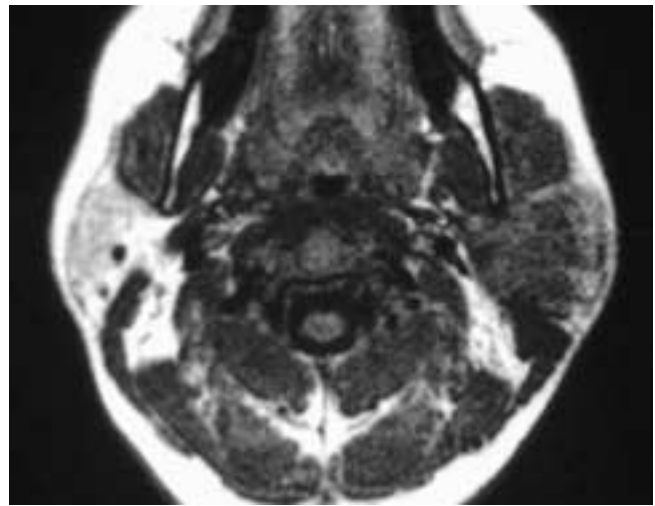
Axial T1-weighted MR image shows a poorly defined low signal intensity mass in the left parotid gland. The mass also had low T2-weighted signal intensity. The imaging appearance is that of a high-grade tumor. This patient had an SCC.
